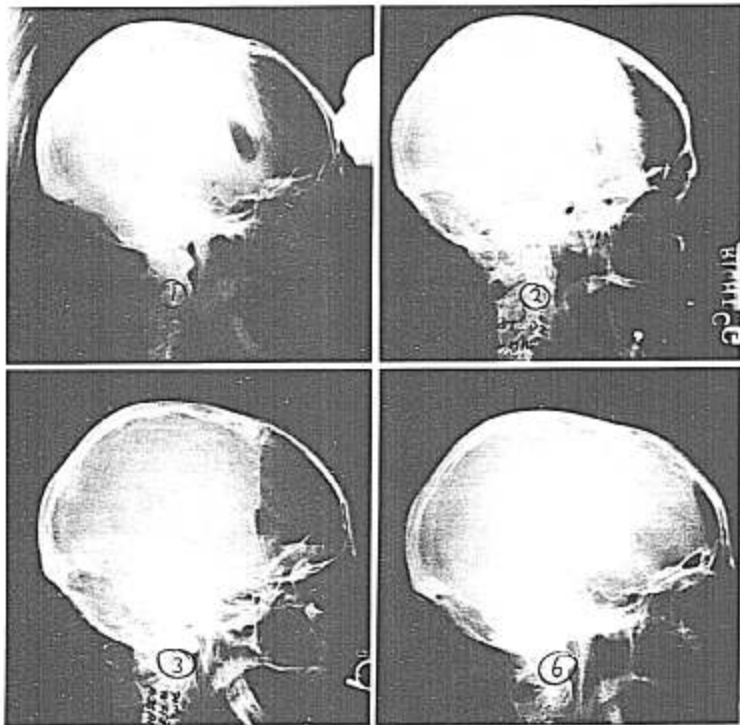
(*above, left*). Brow-up, lateral skull x-ray taken in recovery room. Note subdural air pocket and compression of the frontal lobes. One hemisphere can be seen to be more compressed than the other.
